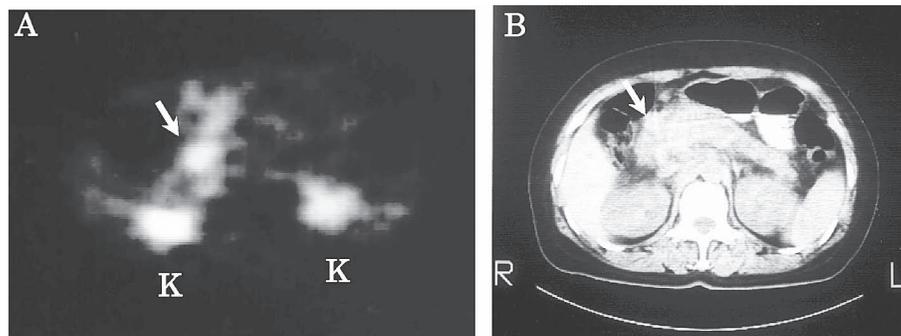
PET imaging of pancreatic cancer with  $^{18}\text{F}$ -FDG.
